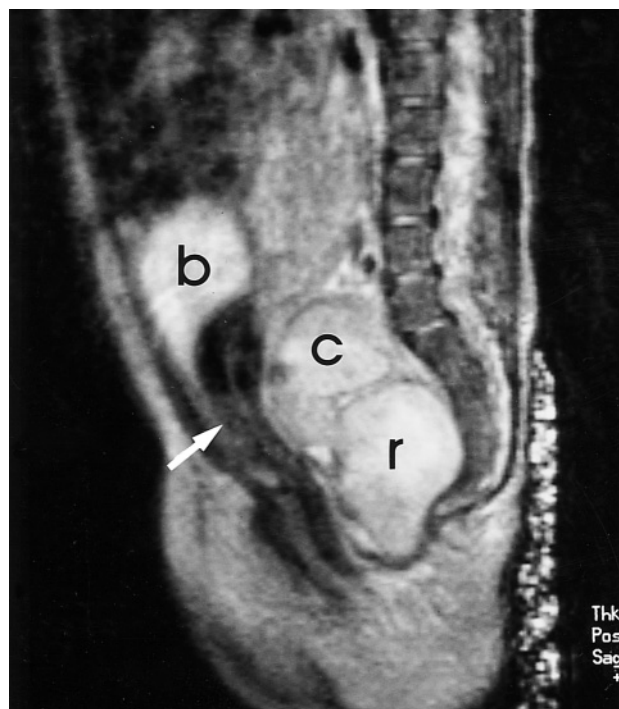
Colonic duplication. T2-weighted spin-echo image in a patient with colonic duplication. The uterus (arrow) and bladder (b) are anteriorly displaced by two fluid-filled viscous structures that represent the rectum (r) and the duplication cyst (c).
